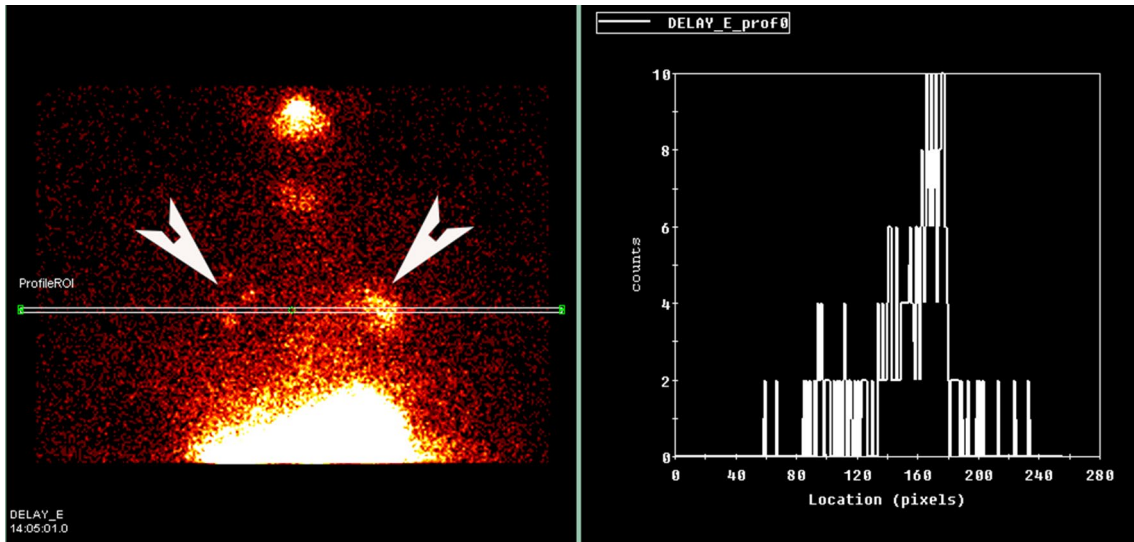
Left of the screen is a delayed scintigraphy study showing aspiration of tracer into both lungs (white arrowheads) and the double white-line marking for computer-generated isotope count. Right
